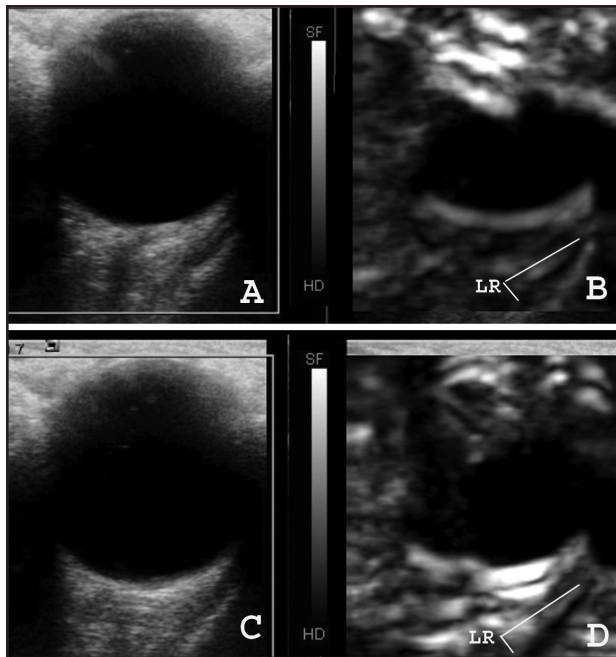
Transverse B-scan images (A and C) and respective grayscale ultrasound elastographic images (B and D) of an eye in primary position (A and B) and abduction (C and D). The lateral rectus muscle (LR) is shown with decreased luminosity (less elastic) in abduction compared with primary position. The gray scale from white (more elastic) to black (less elastic) is also shown.
